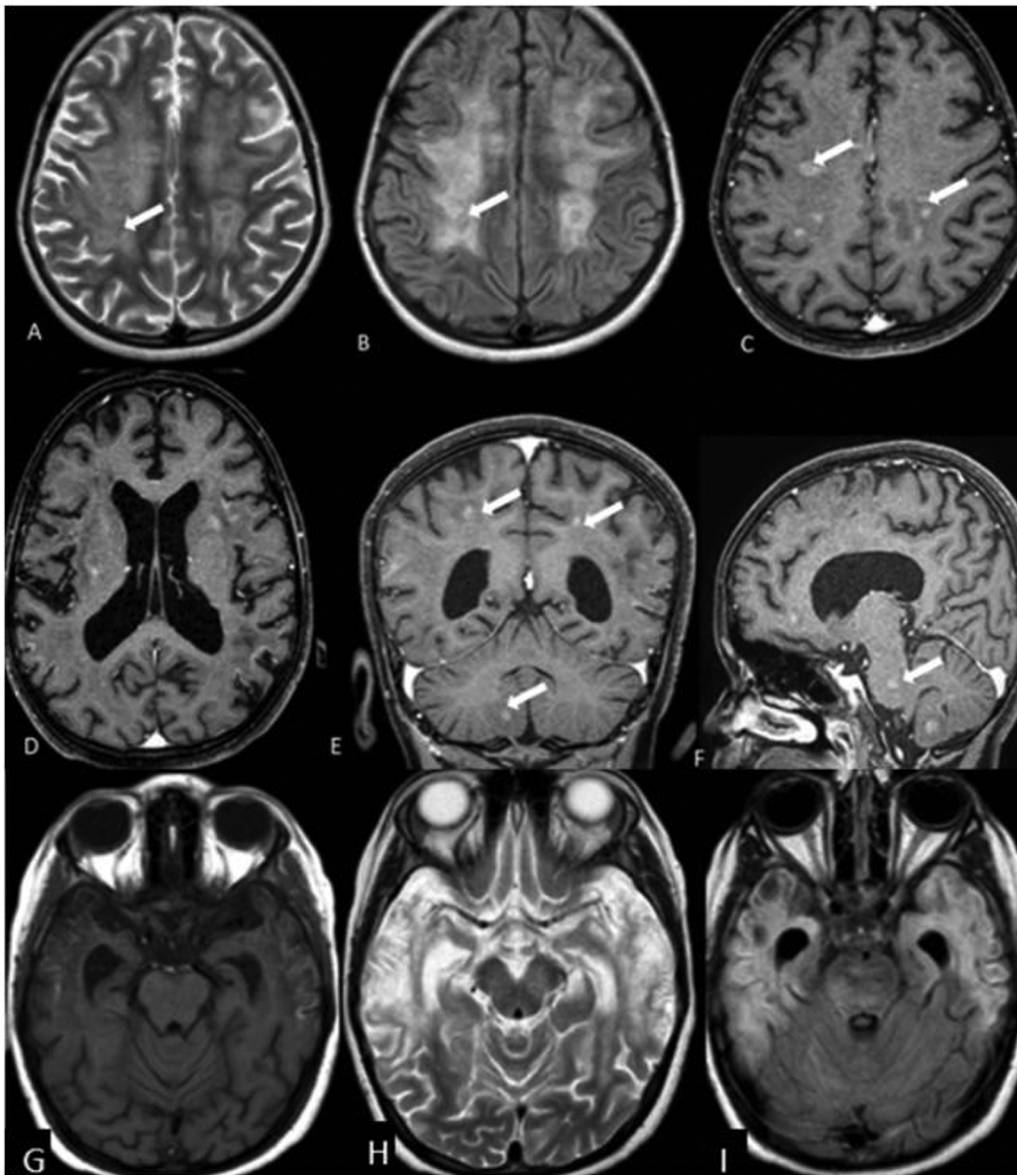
Case 2: (A) Axial T2 and (B) axial fluid-attenuated inversion recovery (FLAIR), (C) and (D) axial postcontrast T1, (E) coronal postcontrast T1, and (F) sagittal postcontrast T1 showing ill-defined heterogeneous lesions involving bilateral fronto-parieto-occipital cortices, bilateral subcortical, and deep periventricular white matter, bilateral basal ganglia, corona radiata and centrum semiovale, pons, brain stem, and right cerebellum (white arrow). The lesions appear heterointense on T2 and FLAIR images. No signal loss is seen on gradient imaging (not shown here). On contrast administration nodular enhancement is seen. No mass effect or midline shift is seen. (G) Axial T1W T1-weighted (T1W), (H) axial T2W, and (I) axial FLAIR showing cystic encephalomalacia with gliosis, volume loss, and cortical laminar necrosis in bilateral temporal gyri.
